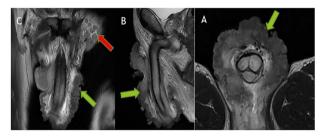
MRI of the penis (A: Axial T2 sequence, B: Sagittal T2, C: Coronal T2) showing a perineal and penile protruding process with lobulated contours surrounding the penis, resembling a cauliflower appearance in intermediate T2 signal (Arrow).
